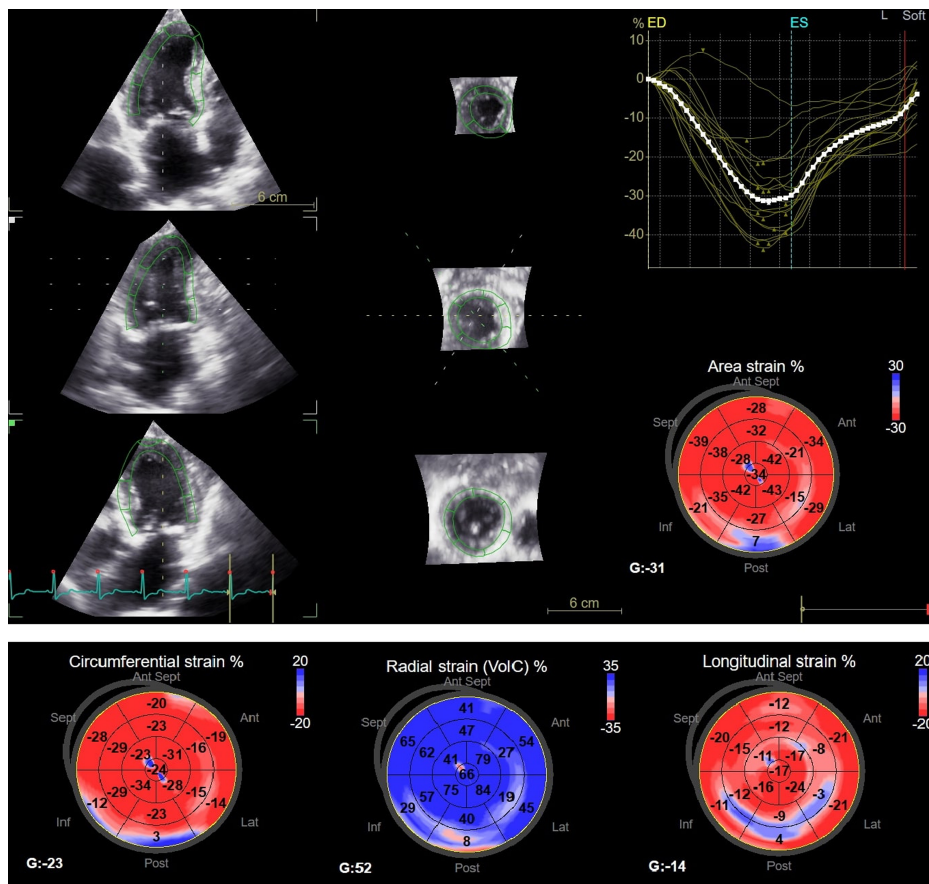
Four-dimensional (4D) speckle tracking echocardiography showing the measurements of the left ventricular global area strain (GAS), global circumferential strain (GCS), global radial strain (GRS), and global longitudinal strain (GLS)
